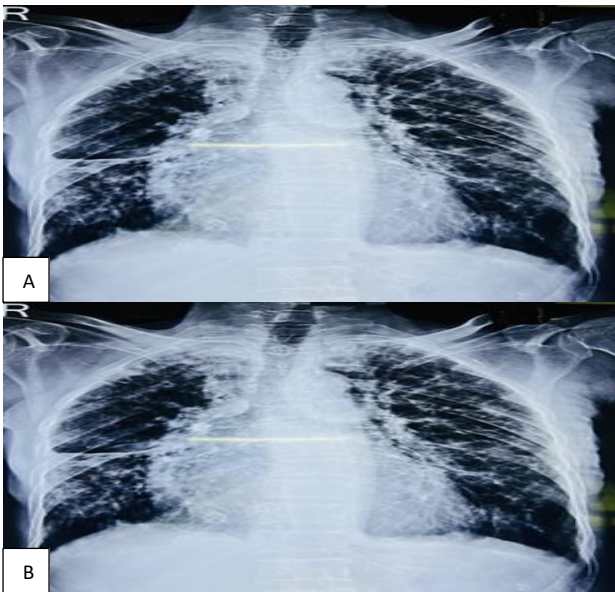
(A and B): Chest radiograph (posteroanterior view) showed fibrotic scarring with associated bronchiectatic changes diffusely in both lungs and an ill-defined opacity in right middle zone.
